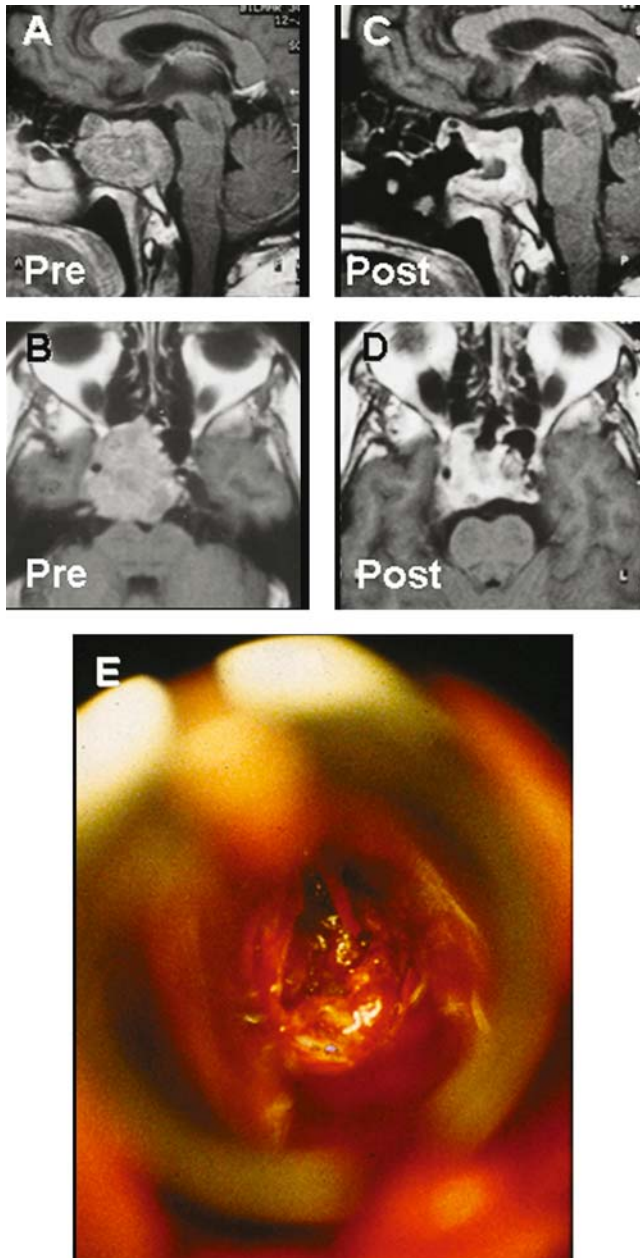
Standard transseptal transsphenoidal approach to the sella for removal of a sellar chordoma. A and B represent sagittal and axial preoperative T1w contrast enhanced MRI's. C and D are the corresponding postsurgical 26th month images. E shows the visualization of the chordoma through the transnasal transseptal exposure
